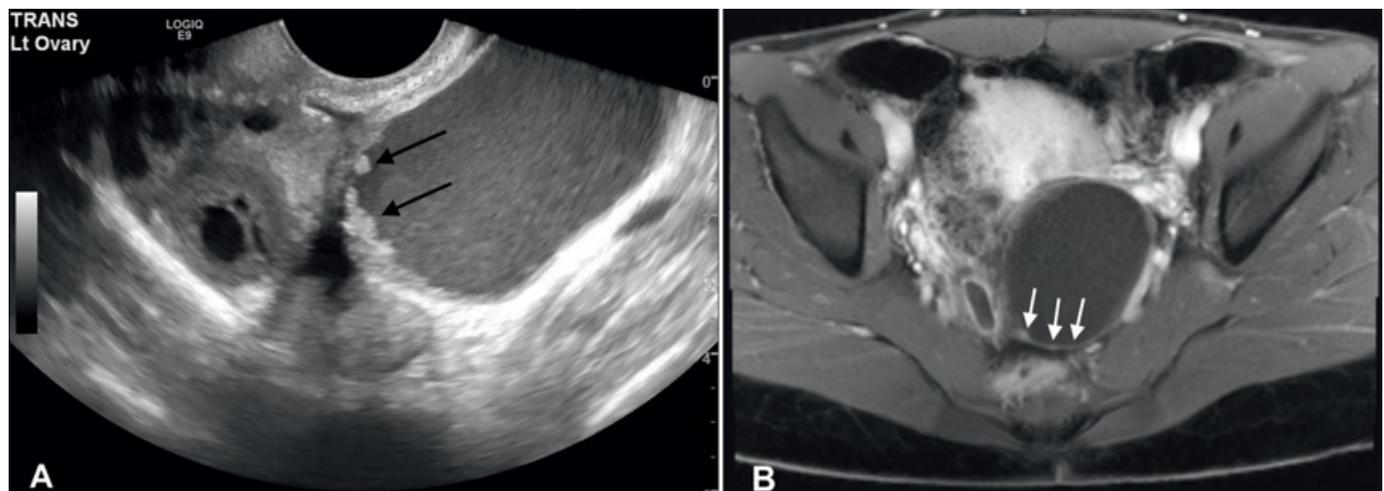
(A) Pelvic US demonstrating cystic ovarian lesion with papillae (black arrows). (B) Pelvic MRI demonstrating cystic ovarian lesion with tiny enhancing nodules (white arrows). Pathology demonstrated mucinous borderline tumor.
